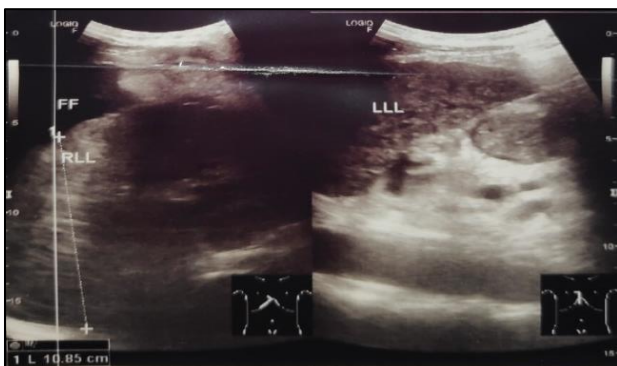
Abdominal ultrasound imaging showed small liver with irregular edges.
